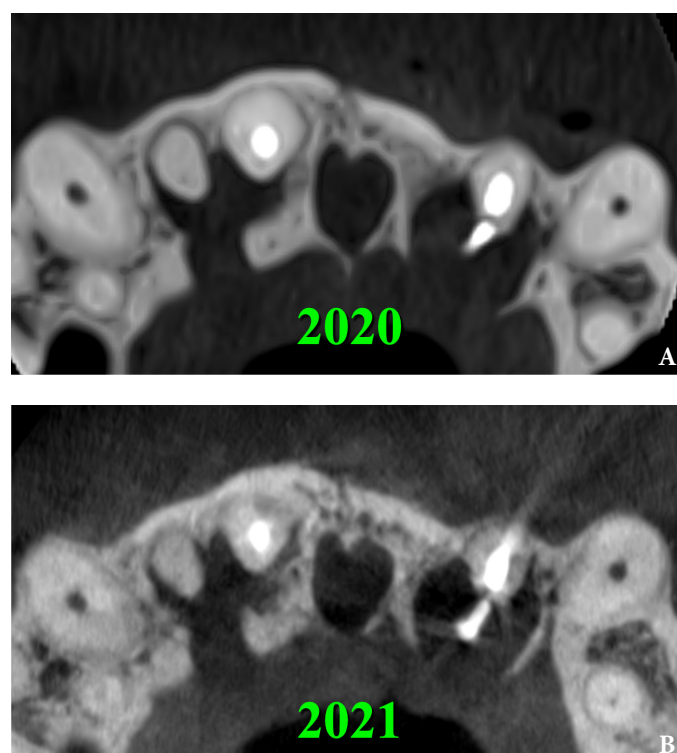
Comparing the axial CBCT scans for 2020 (A) and 2021 (B), we can say that there is no increase in periapical radiolucency in areas of the teeth 12, 11, and 22. 12, upper right lateral incisor; 11, upper right central incisor; 22, upper left lateral incisor.
